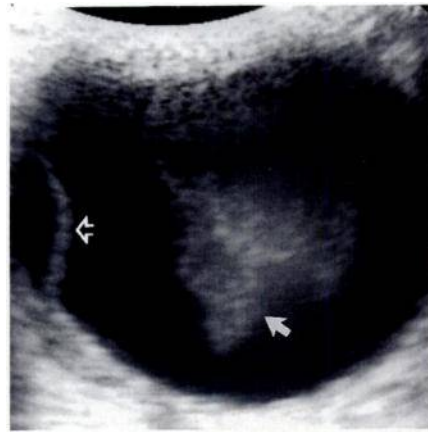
Focal retinal detachment (open arrow) and vitreous hemorrhage (solid arrow) shown by axial sonogram. This vitreous hemorrhage was mobile on dynamic scanning.
